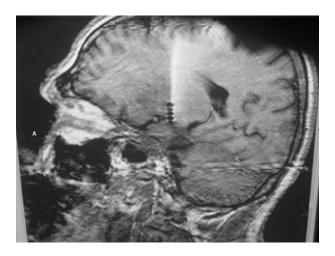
Post-operative MRI showing the DBS lead in the STN
